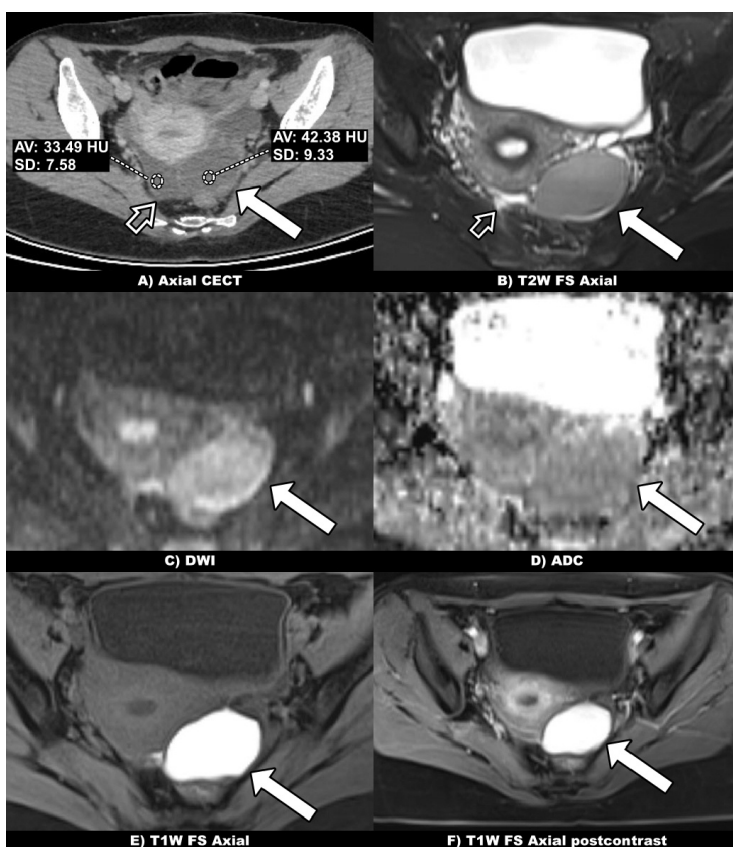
MRI images of a hemorrhagic cyst.
